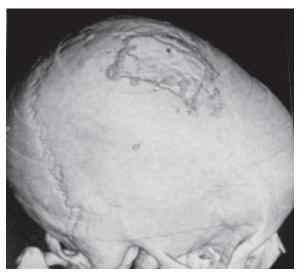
Post operative 3-D CT shows good repair of bony gap by cranioplasty flap.
